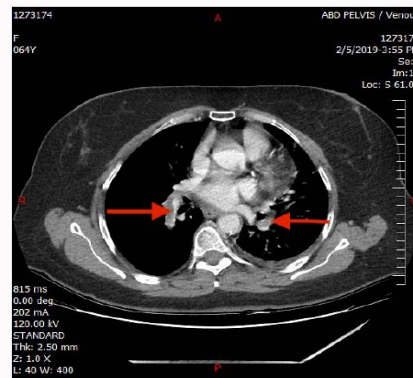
Computed tomography axial view showing bilateral pulmonary embolism (arrows).
